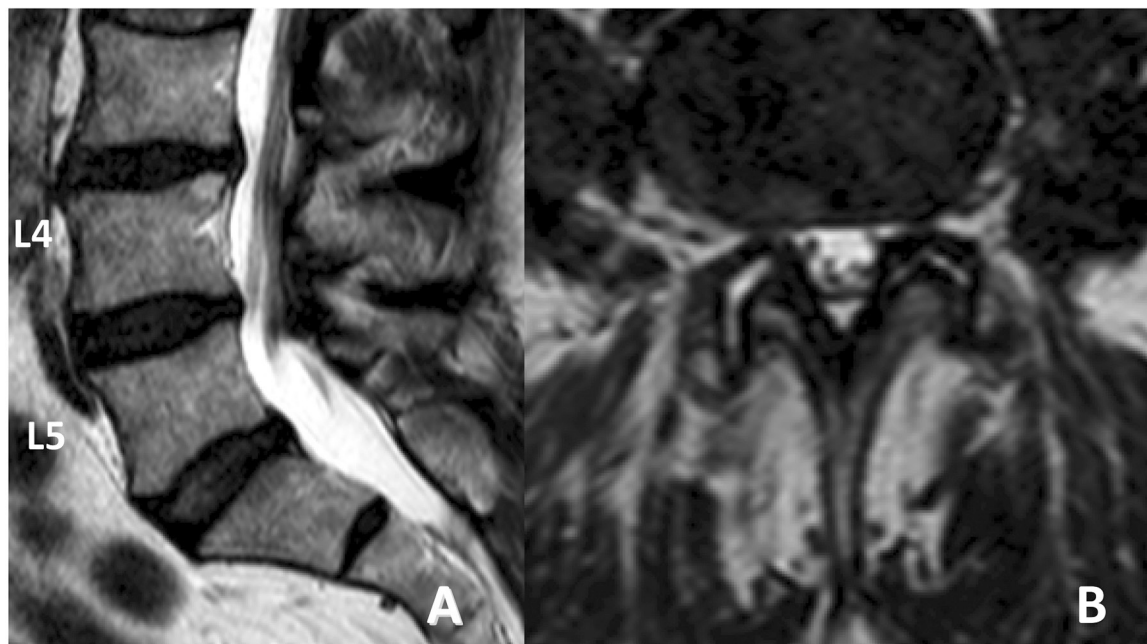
A) T2 sagittal and B) axial CT images demonstrating no synovial cyst recurrence.
